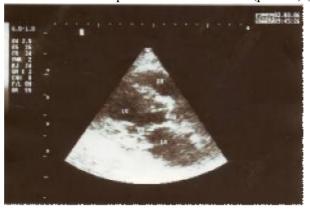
Two-dimensional four chamber view echocardiography reveals aortic thickening and calcification from the same patient in figure 3
